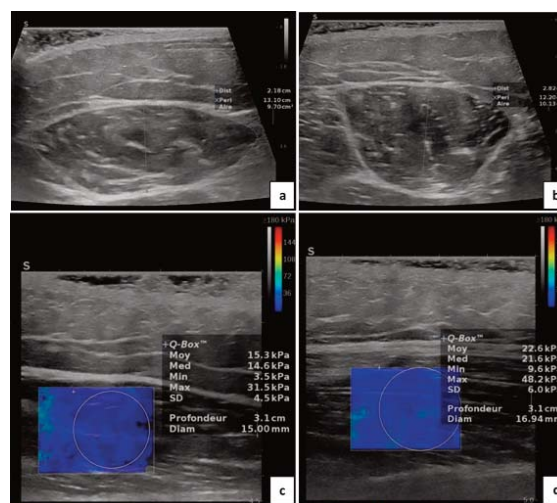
Ultrasound/elasticity of the rectus femoris in the rested (a and c) and passively stretched (b and d) positions. Images a and b show the measurement of variables in B-mode (transverse section): thickness (Dist) and surface area (aire). Images c and d in SWE mode (longitudinal section) show the elasticity module of the muscle by giving an average value (Moy) of the colour map within the circle chosen by the operator (Q-Box).
